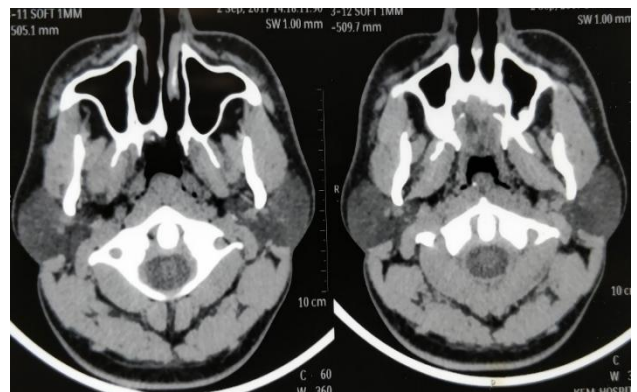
CT scan of paranasal sinuses with nasopharynx showing cystic mass in nasopharynx.
